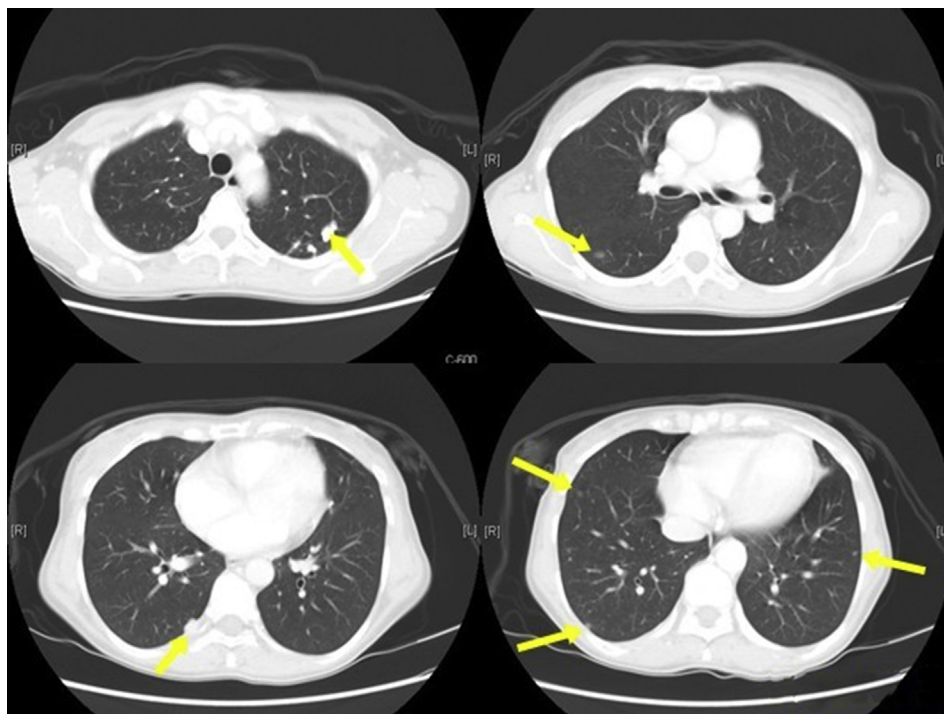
Abdominal computed tomography revealed multiple metastases in the bilateral lower lungs.
